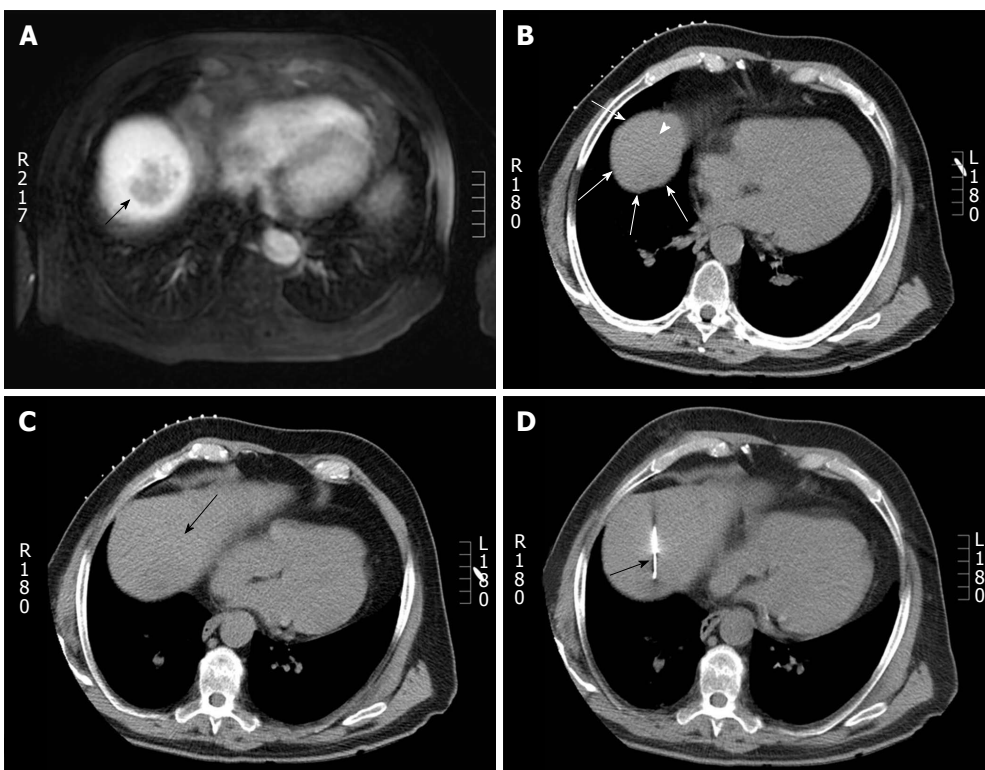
Computed tomography guided biopsy in a 65-year-old man. A: Axial post gadolinium magnetic resonance imaging shows a 4 cm hepatic dome lesion; B: On preprocedural CT, the lesion in the high dome is surrounded by lung (arrow head) on all sides. Pulmonic transgression was not possible as the patient had severe emphysema; C: The CT gantry was angulated in the craniocaudal direction (20 degrees) which created a safe path to the tumor from the anterior aspect (arrow); D: Axial intraprocedural CT image shows biopsy needle within the lesion (arrow). Biopsy: Hepatocellular carcinoma. CT: Computed tomography.
